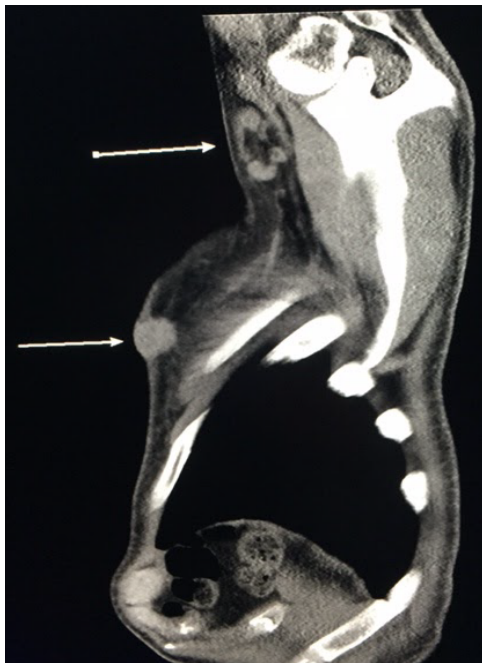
CT scan - Sagittal view showed the left chest wall mass and the suspicious left axillary lymph nodes (arrows).
